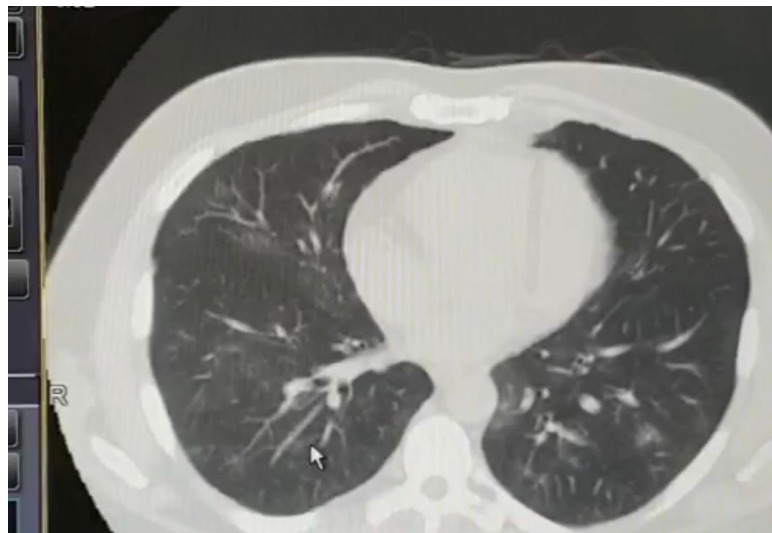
The patient's CT scan after seven days of the treatment with heparin and antiviral medications
